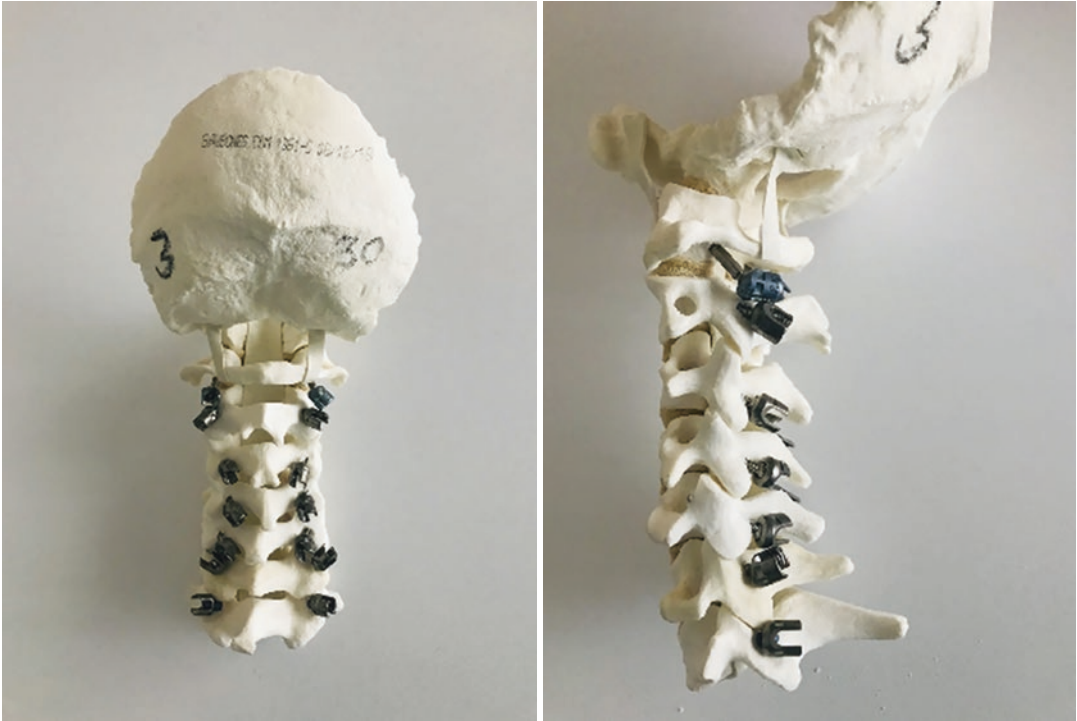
All sawbones underwent CT imaging and all screw pathways were analyzed
